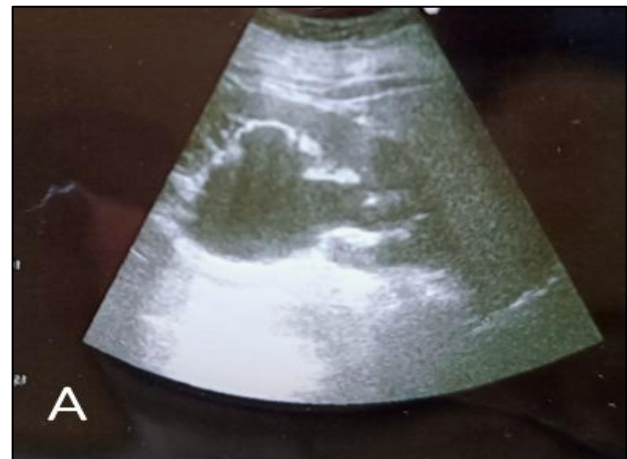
Ultrasonography of right kidney before (A) after two weeks from surgery (B).
